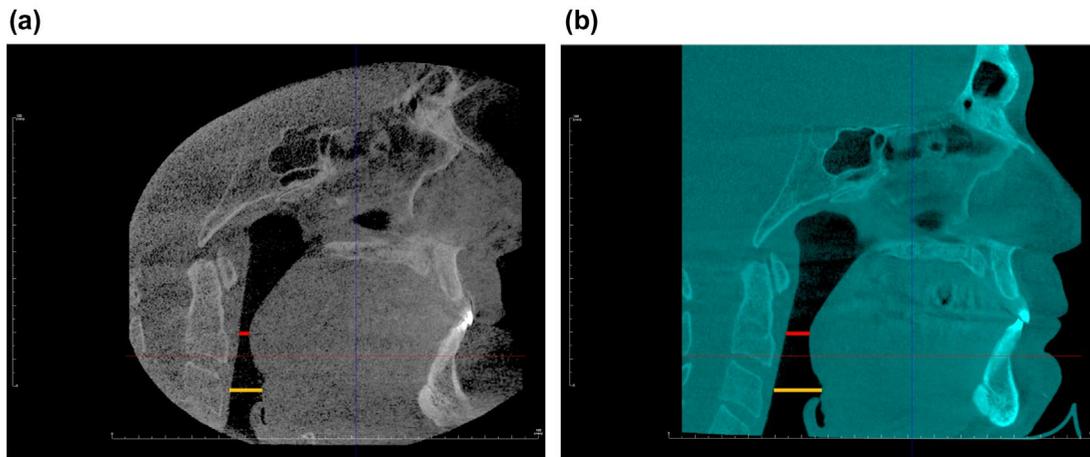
a. Pre-treatment mid-sagittal slice from 3D CBCT scan, showing minimum, mid-sagittal retropalatal distance of 3.44 mm (red line) and the minimum mid-sagittal retroglossal distance of 10.77 mm (orange line). b. Post-treatment mid-sagittal slice from 3D CBCT scan, showing improvements in the minimum, mid-sagittal retropalatal distance to 8.44 mm (red line); and the minimum mid-sagittal to 17.97 mm (orange line).
